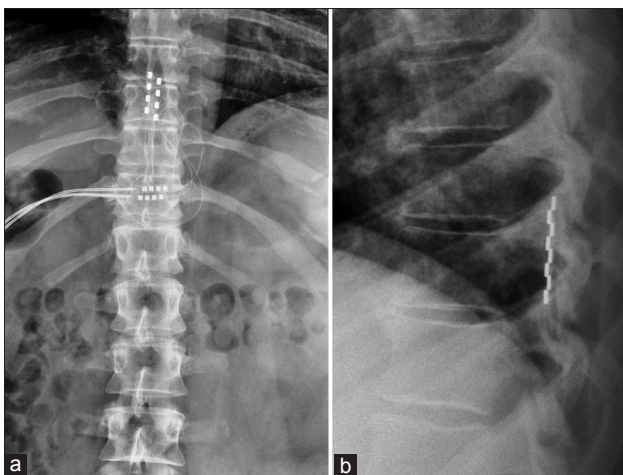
(a) A-P view of postoperative X-ray show a 4 + 4 surgical lead placement at T8-T9, (b) The L-L view of the dynamic X-ray in flexed position does not show any sign of vertebral instability
